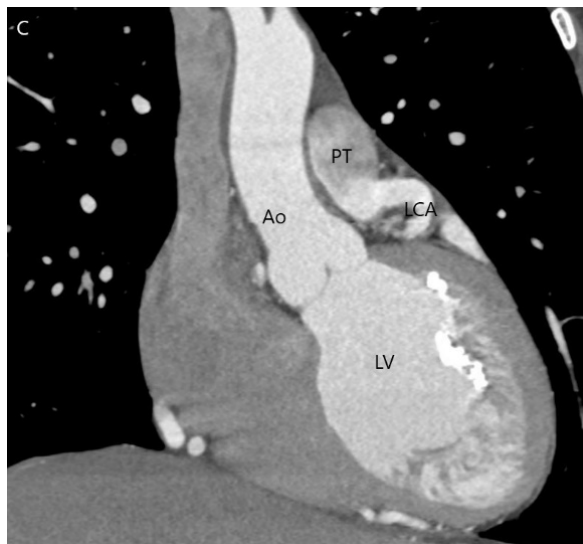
Cardiac angio CT image. Ao — aorta, PT — pulmonary trunk, LV — left ventricle, LCA — left coronary artery
